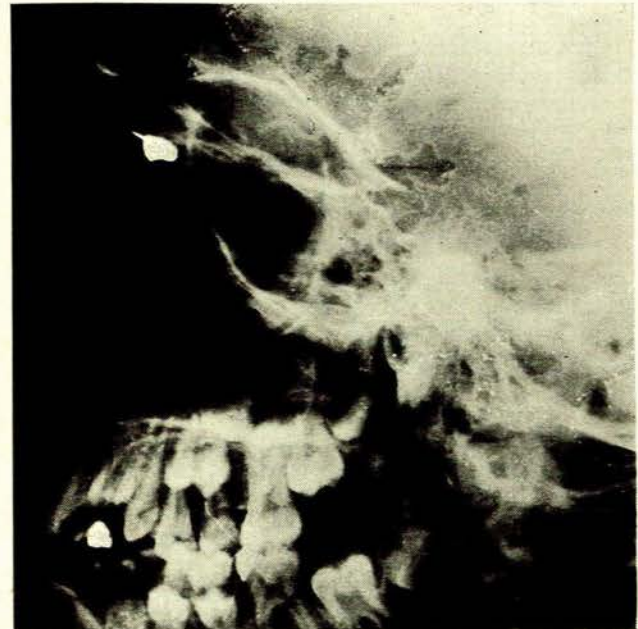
Lateral facial radiograph showing pellet lying in right orbit.
